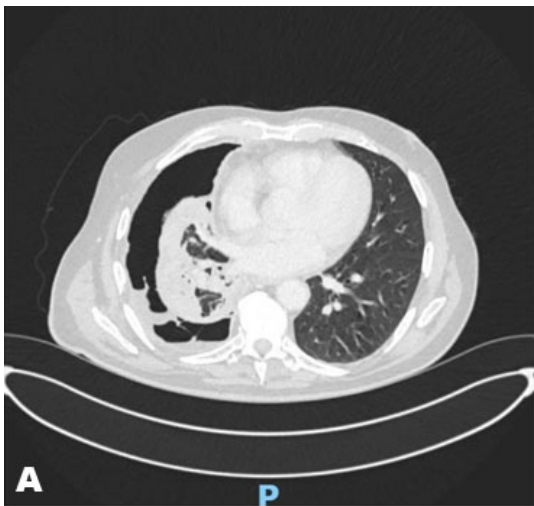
(A and B) Slices of the chest CT with a moderate pleural effusion (fluid at the bottom of the CT scan) with a hydropneumothorax (presence of air in the hemithorax), air locules (pockets of gas in the fluid), and pleural enhancement.
